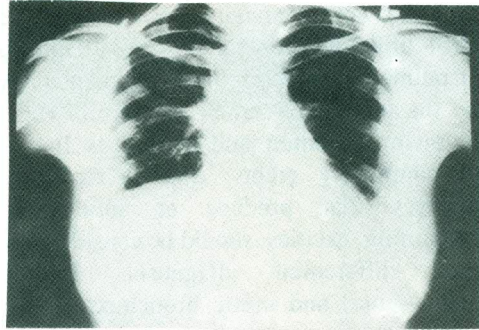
Postoperative chest x-ray for the same patient in Fig. (14) Exploration was done through median sternotomy with enucleation of the simple cyst in the left lower lobe and right upper lobectomy.
